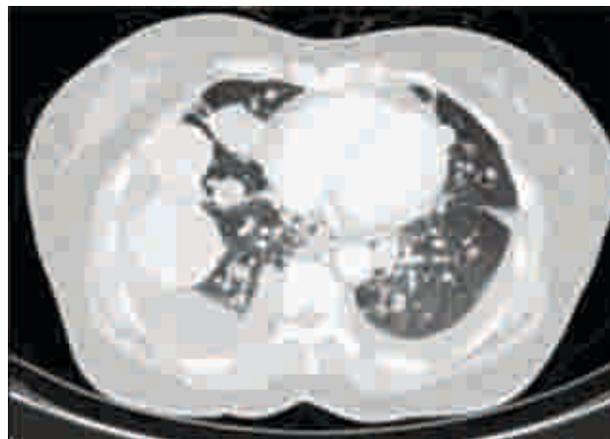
Cross-Sectional Image of CT Chest Showing Innumerable Well-Demarcated Lung Masses with Bilateral Pleural Effusion, and Lymphadenopathy
